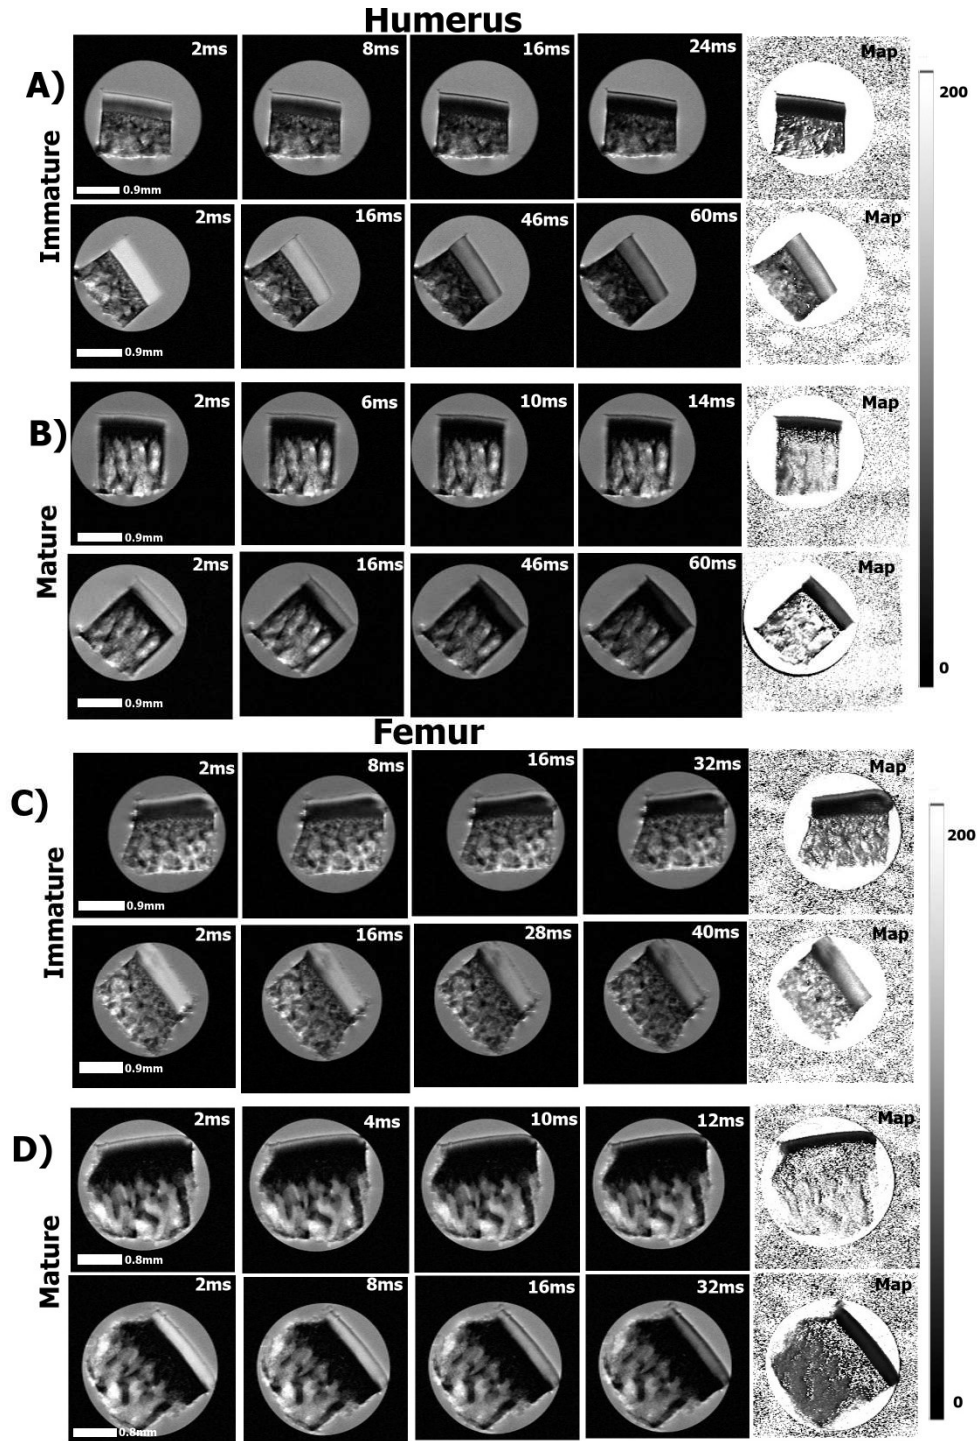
MRI images of immature (a, c) and mature (b, d) cartilage blocks from humeri (a, b) and femurs (c, d) at 0° and 55° orientations to the magnetic field (B_0), which points vertically up, respectively. The first four columns contain T2 weighted intensity images, while the last column contains the calculated T2 images. All relevant images are plotted on the same greyscale.
